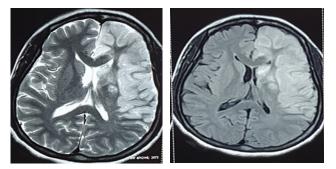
MRI of brain showing left sided acute cerebral infarct
